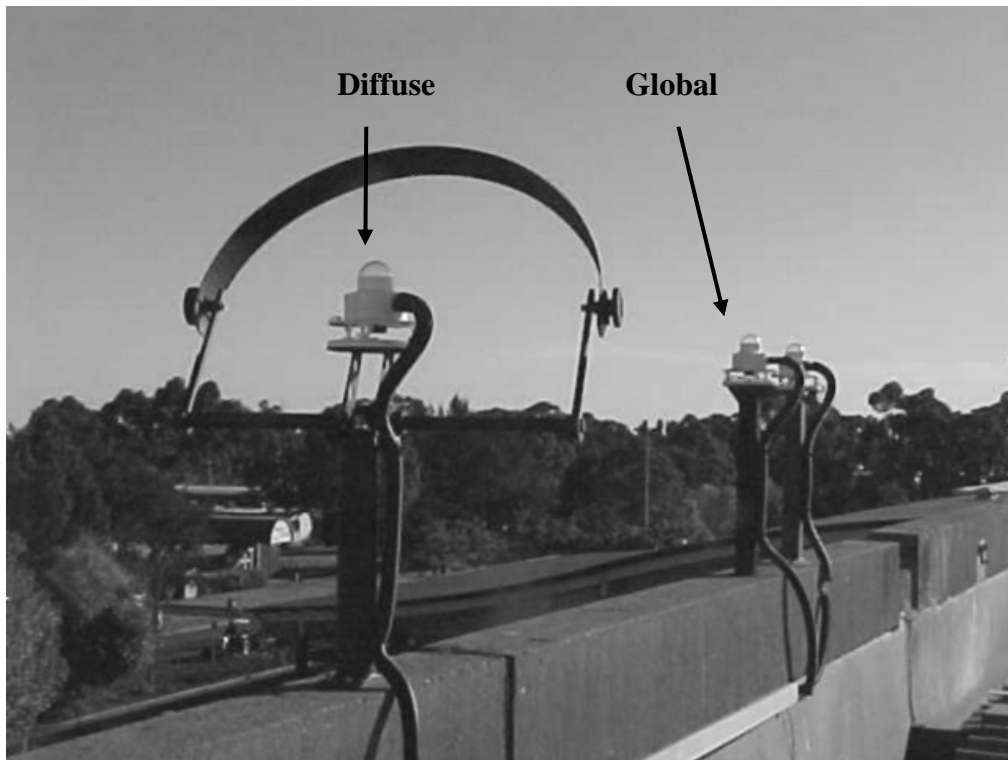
Diffuse and global SUV meters.
